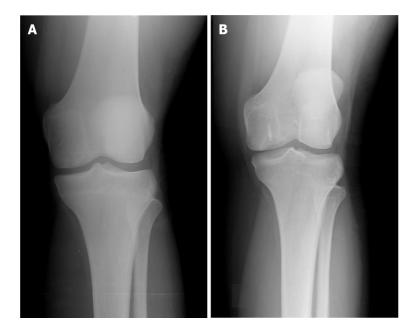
Radiographic images of a patient treated with the Autologous Tendon Transplantation technique. A: Anteroposterior radiograph of the knee of a 24-year old female with a symptomatic lesion of the medial femoral condyle (4.6 cm² size and 1.4 cm depth); B: Anteroposterior radiograph of the knee 6 years after autologous tendon transplantation with suture anchor show congruency of the articular surface of the medial femoral condyle. There are no arthritic changes. The patient is asymptomatic, free from pain and has no limitation of movement.
